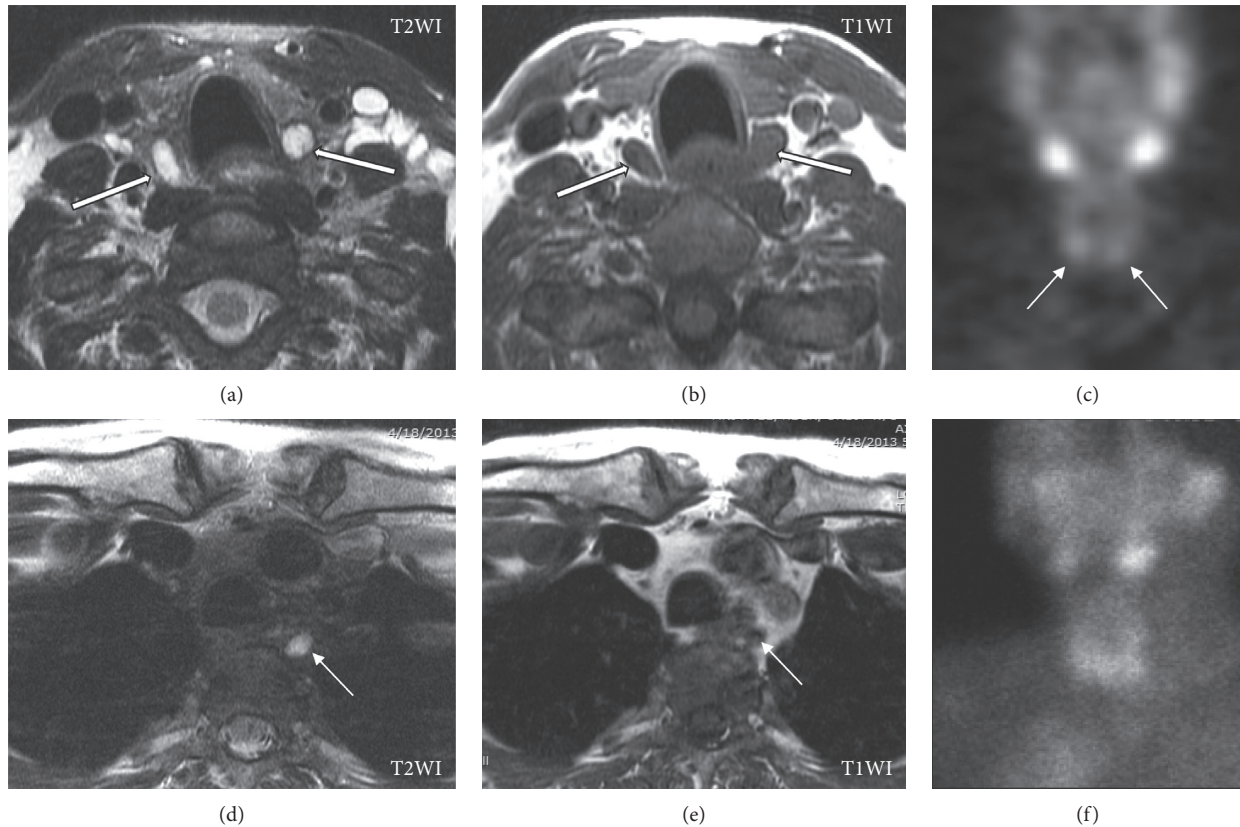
Parathyroid adenomas on magnetic resonance imaging (MRI). A 67-year-old female presents with persistent hyperparathyroidism after initial bilateral inferior parathyroidectomy. Unenhanced MRI (due to allergy to iodine- and gadolinium-based contrast materials) shows well-circumscribed bilateral inferior T2WI hyperintense (a) and T1WI hypointense (b) adenomas (white arrows) posterior to the inferior thyroid lobes. Planar delayed (two hours) single-photon emission computed tomography (SPECT) (c) demonstrates focal radiotracer accumulation (white arrows) along the inferior margin of the thyroid lobes. Further review of the MRI reveals small T2WI hyperintense (d) and poorly defined T1WI hypointense (e) nodules in the left posterior mediastinum/prevertebral region corresponding to an overly descended left superior parathyroid adenoma not demonstrated on initial SPECT studies (c, f).
